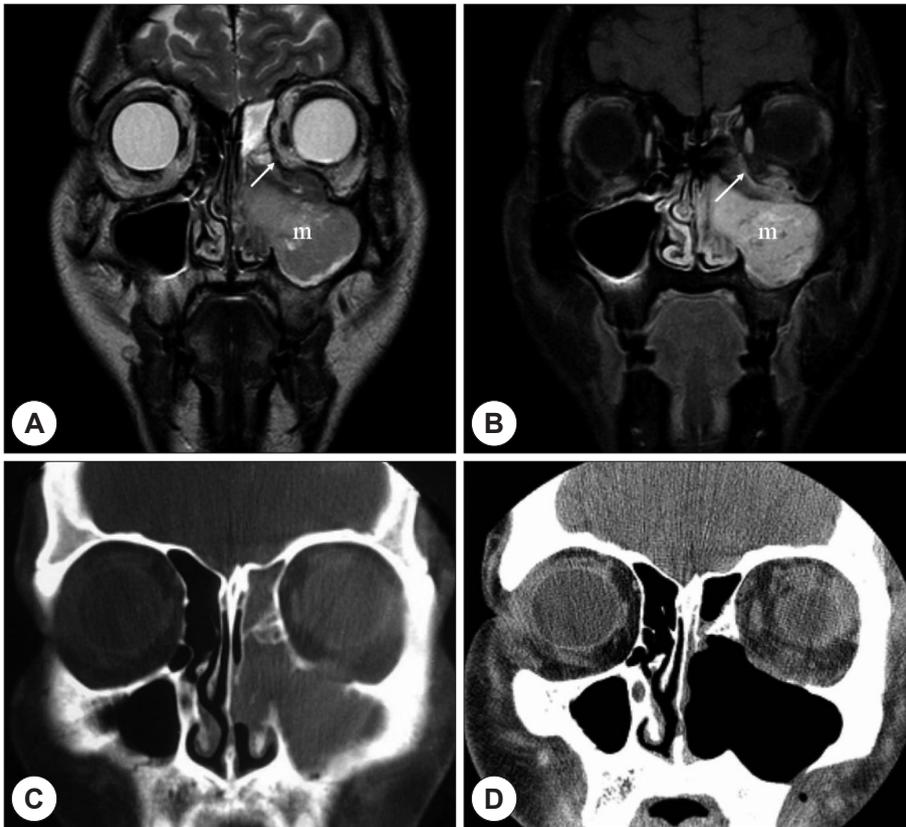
CT/MRI of case 3. The thickened periorbital (arrow) shows lower signal intensity than that of the mass (m) and left frontal and ethmoidal sinus shows high signal intensity on T2-weighted MR coronal image (A). Gadolinium-enhanced T1-weighted MR coronal image reveals that the thickened periorbital (arrow) is less enhanced than the extraocular muscles or the mass (B). The periorbital is not able to be discerned on coronal CT images (C), and the mass seems to invade the orbital fat beyond the orbital bone defect. There is no evidence of residual or recurrent tumor on follow-up coronal CT images after 12 months (D).
